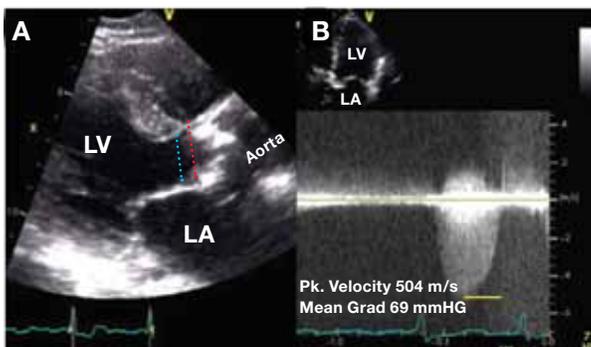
Transthoracic echo is used to assess AS severity and aortic annular diameter. (A) LVOT diameter (blue line) is usually used to derive LV stroke volume whereas aortic annular diameter (red line) is used for to determine appropriate prosthetic valve size. (B) Continuous wave Doppler recording is used to measure peak velocity and mean transvalvular gradient across the aortic valve.
